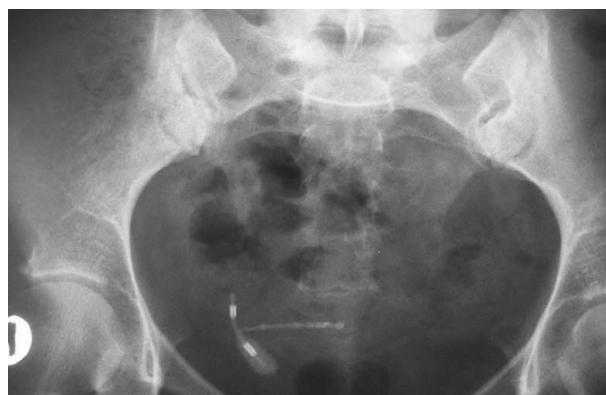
Migrated intrauterine device and stone seen on pelvic plain radiography.
